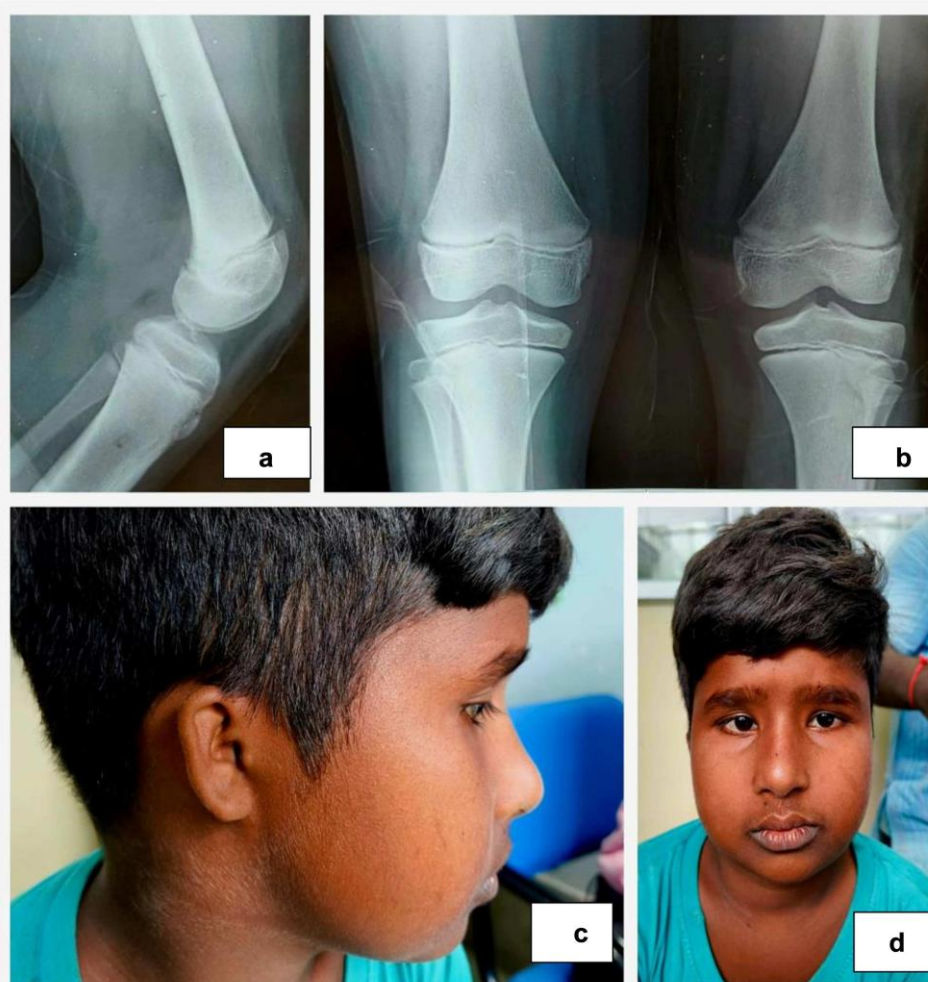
Radiographs (skiagrams) and clinical images of Case 2—an eleven-year old boy with with Meier-Gorlin Syndrome. (a) Lateral view skiagram of Right knee (b) Anterior view skiagram showing bilateral absent patellae (c). Microtia with narrow ear canal (d) Narrow palpebral fissure, telecanthus, full lips. [Color figure can be viewed at wileyonlinelibrary.com]
